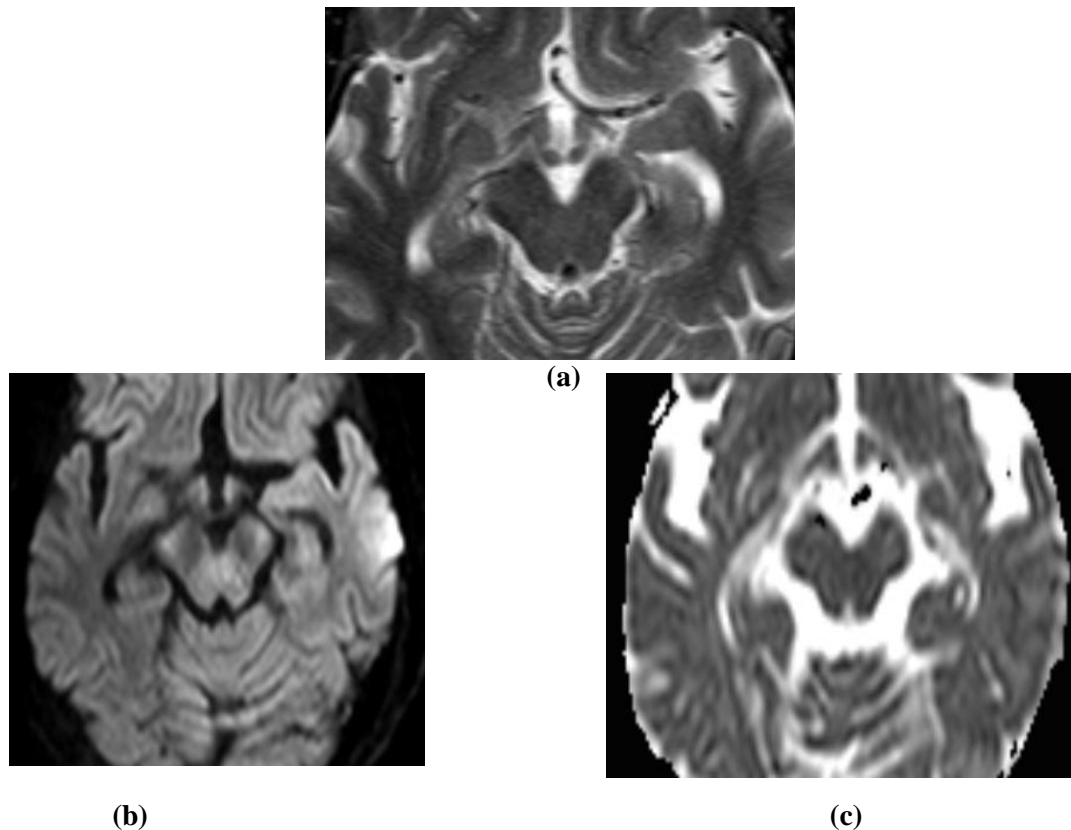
Patient of PD: on (a) Axial T2 weighted view on Midbrain show Thinning and blurring of Substantia Nigra Pars Compacta (SNPC). (b,c) Axial DWI and ADC show normal MRI finding.
